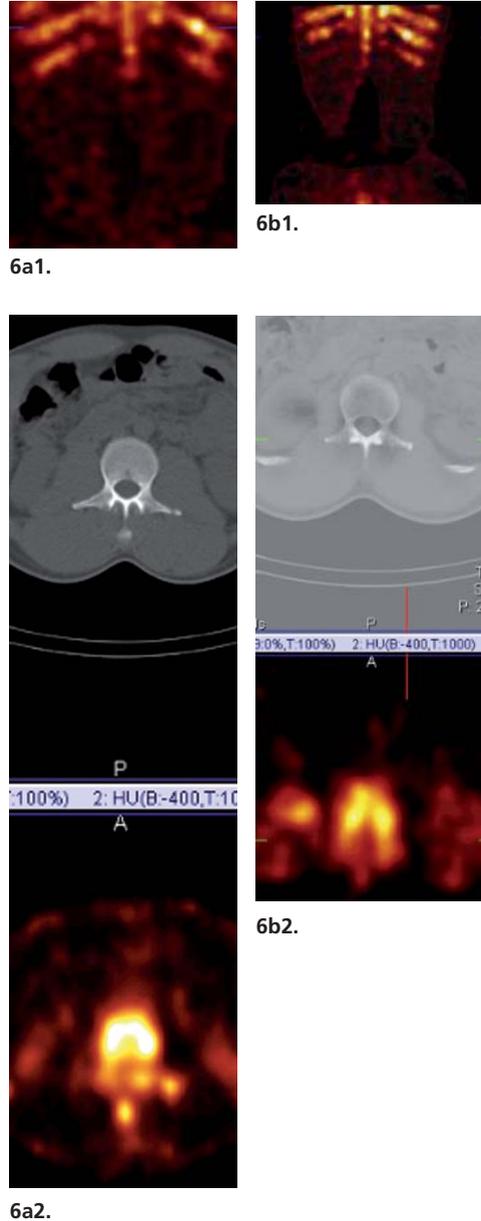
Bone scintigraphy. Case nr. 6.
